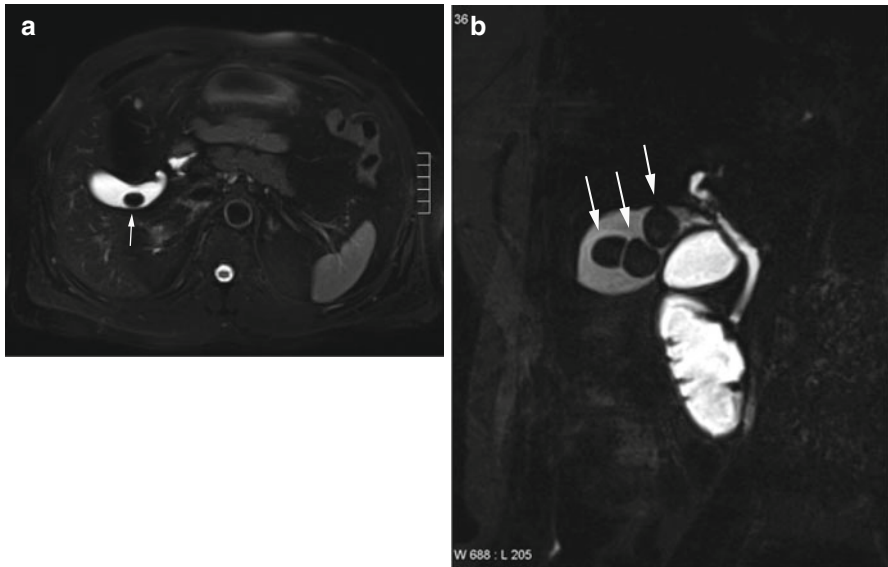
A 62-year-old female subject without symptoms at the time of whole-body MRI screening. Several calculi (*arrows*) are seen within the gallbladder. (a) Axial fat-saturated T2w TSE image depicts bright bile. (b) MRCP can be helpful for detecting calculi near the infundibulum
